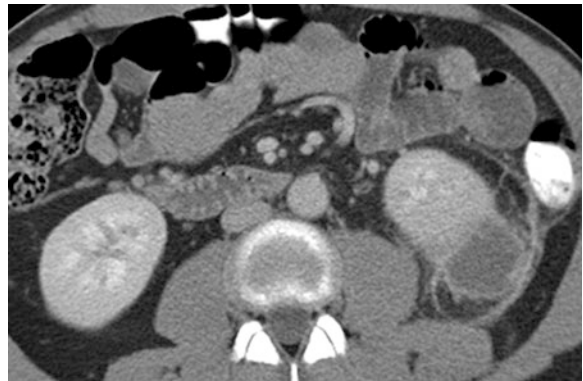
Abscessus with adjacent fat tissue reactions and thickening of Gerota's fascia (CT)
